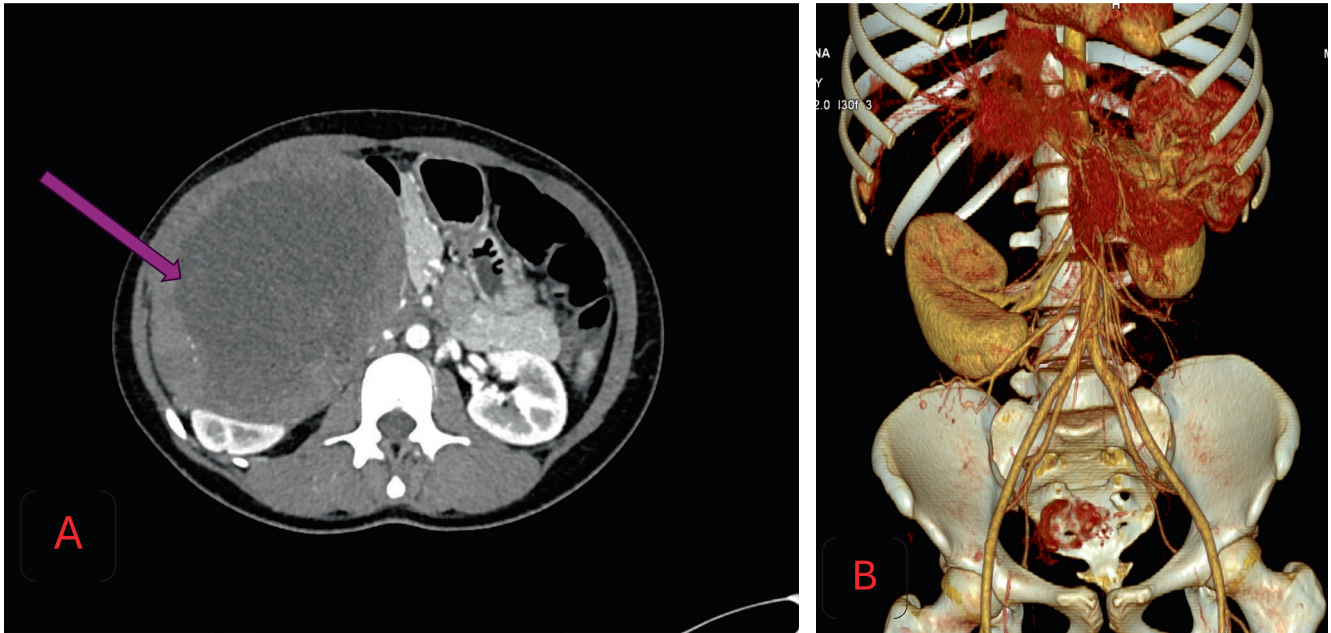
(A) Shows the mass with a diffuse central area of necrosis and several calcific foci; the mass measures 6.3×12.1 cm, consistent with a large right adrenal tumor. (B) Volumetric rendering of a CT coronal view showing a mass effect on the right kidney with clear separation from the tumor.
